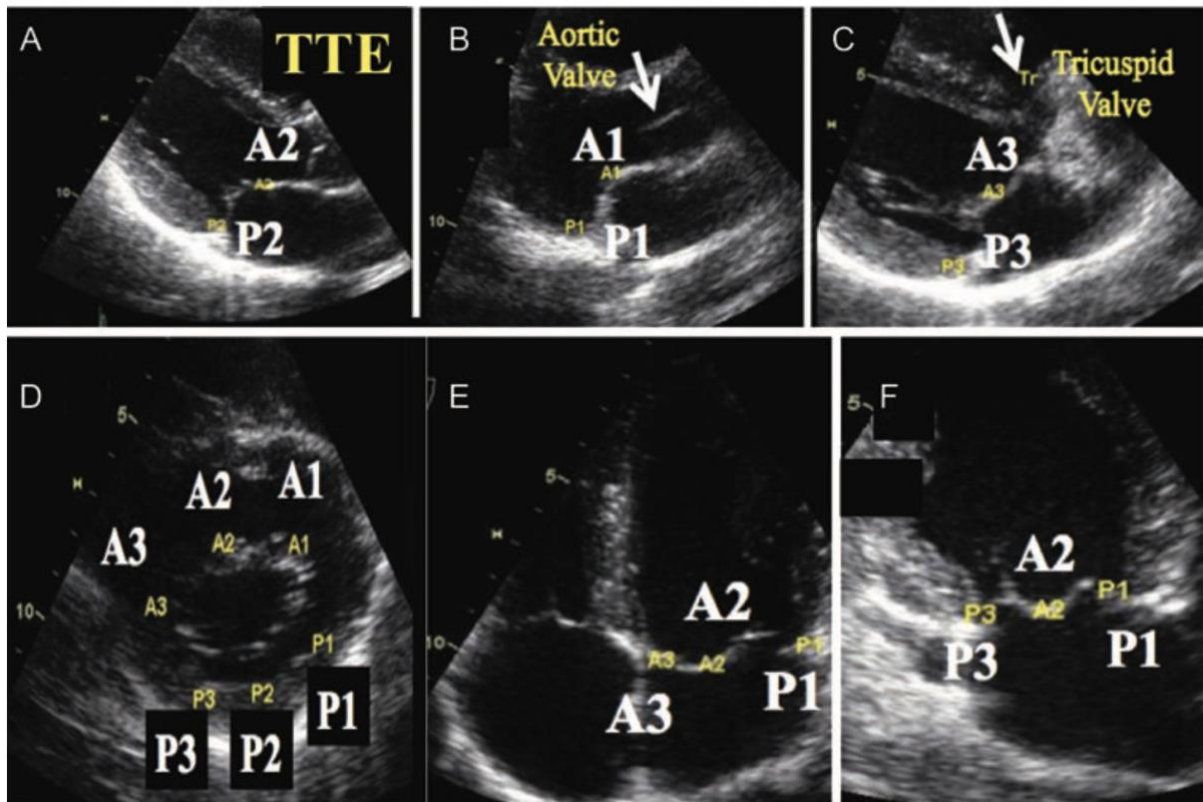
Analysis of the mitral valve in two-dimensional transthoracic echocardiography (TTE). A1-3 describe the scallops of the anterior leaflet; P1-3 describe the scallops of the posterior leaflet. (Lancellotti, Tribouilloy et al. 2013)
